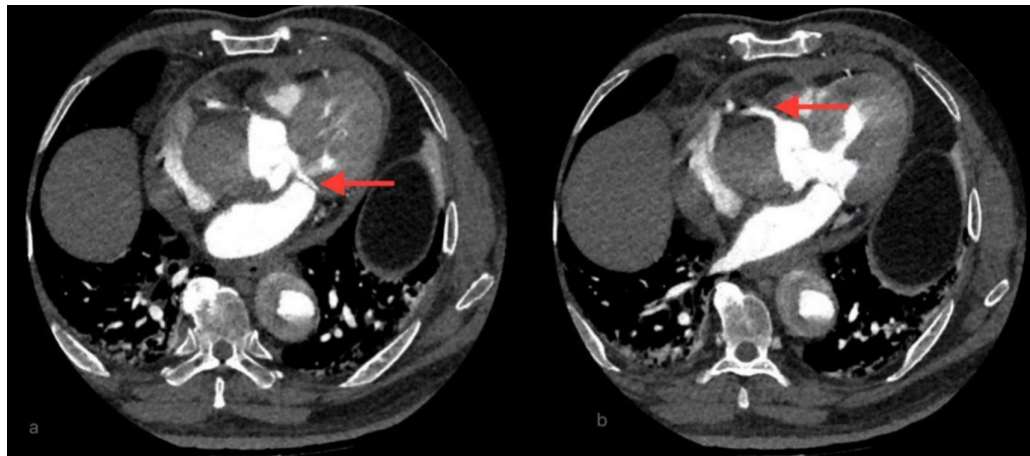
CTA demonstrates proximal segment of right and left coronary artery. At the level of ostia of left coronary artery (A). At the level of ostia of right coronary artery (B).
